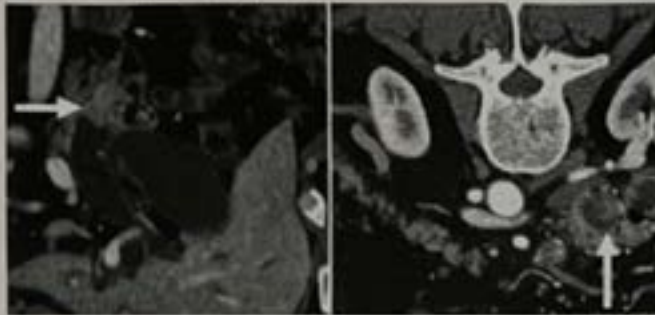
CT image showing distal cholangiocarcinoma (Periampullary carcinoma)
